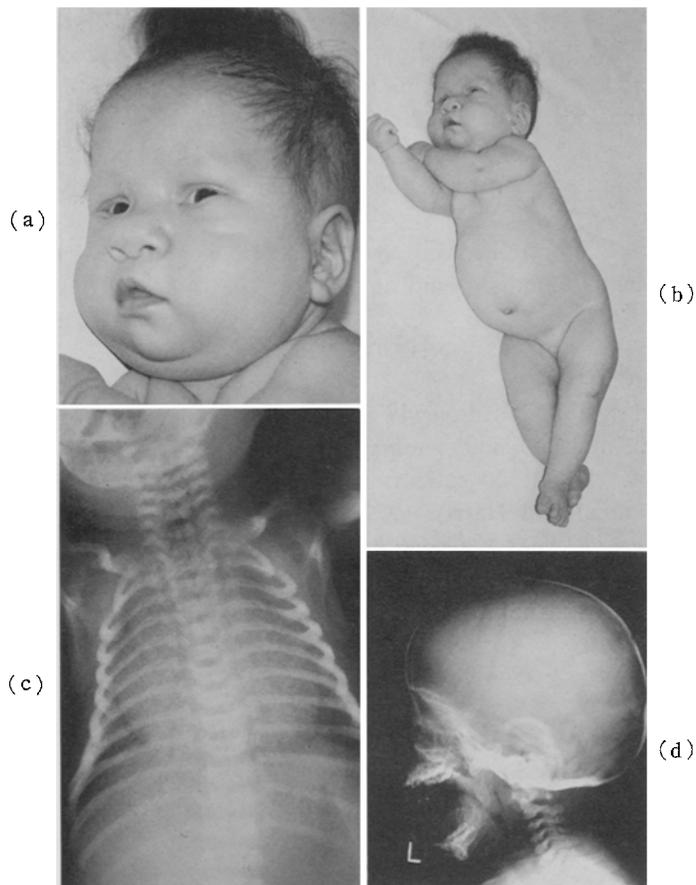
a, Coarse dysmorphic features. b, Narrow thorax and distended abdomen. c, d, Chest and skull X-rays.
